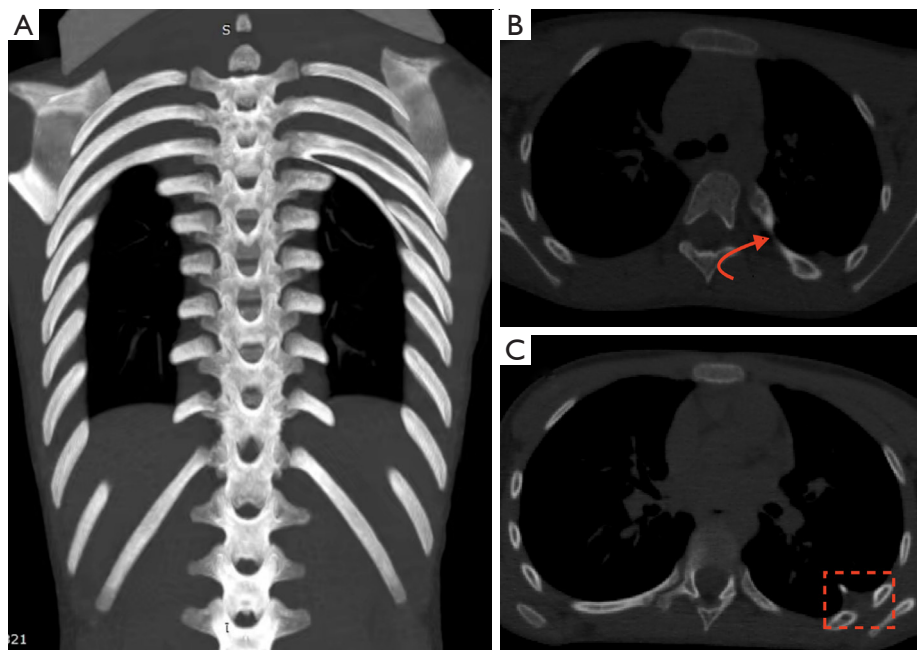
CT image of the intrathoracic rib. (A) Coronal position of the abnormal rib. (B) The arrow points to the origin of the abnormal rib. (C) The pleura within the dashed line is stretched. CT, computed tomography.
